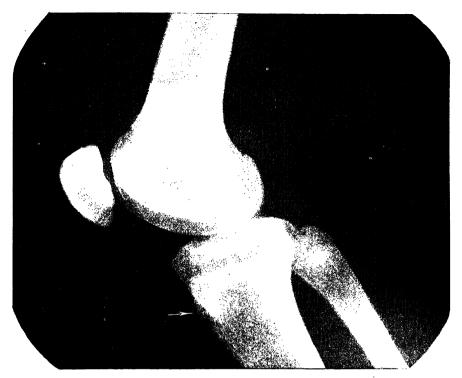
Radiograph of the knee of a boy aged 16 years. Lateral view. Note that the upper epiphysis of the tibia includes the tibial tubercle, which is indicated by the arrow.
